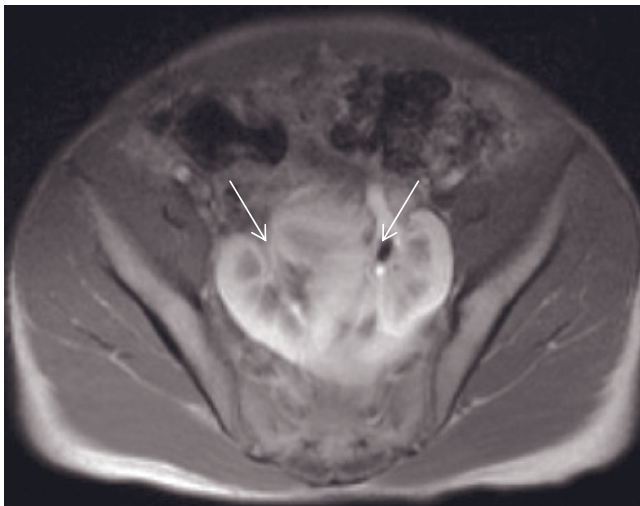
Crossed fused ectopy. Coronal T1-weighted precontrast SE images (a, b) demonstrate fusion of a small inferomedial kidney to the normal-sized and -positioned left kidney. Clear depiction is rendered by the definition of corticomedullary differentiation. The collecting system of the normally positioned left kidney is normal in size (arrow, a), whereas the crossed fused right kidney has a mildly dilated collecting system (arrow, b). Pelvic fused kidneys. Transverse T2-weighted single-shot echo-train
